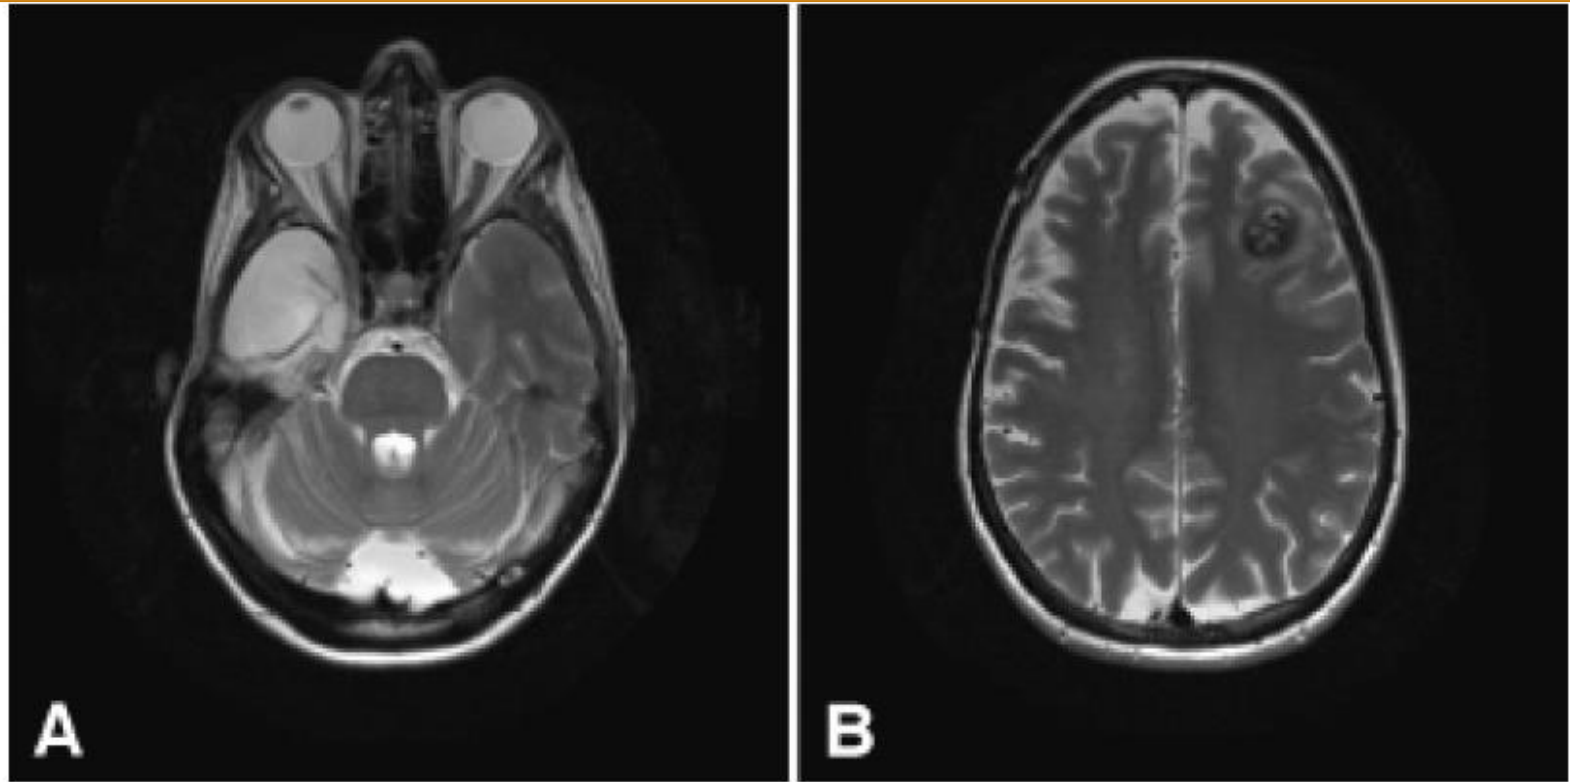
This 40-year-old woman underwent resection of a right temporal anaplastic astrocytoma in 1997, followed by 46 Gy WBRT. An axial T₂-weighted MR image obtained in 2006 demonstrates the right temporal resection cavity from the previous surgery and a small cavernoma in the left temporal lobe (*left*) as well as another cavernoma of the left frontal lobe (*right*).
